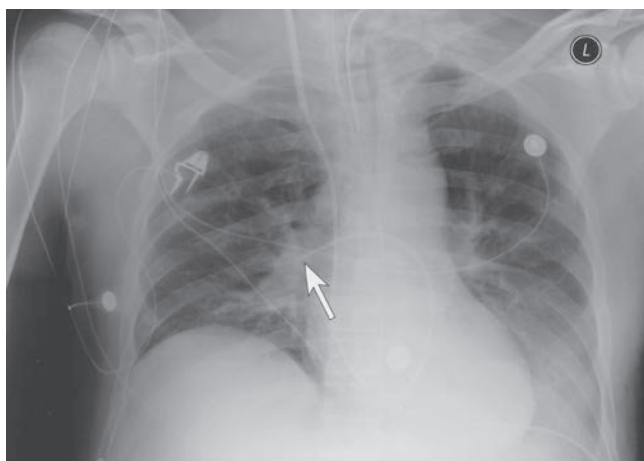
Chest radiograph showing proper placement of pulmonary artery catheter in the pulmonary artery (arrow shows tip of pulmonary catheter).
